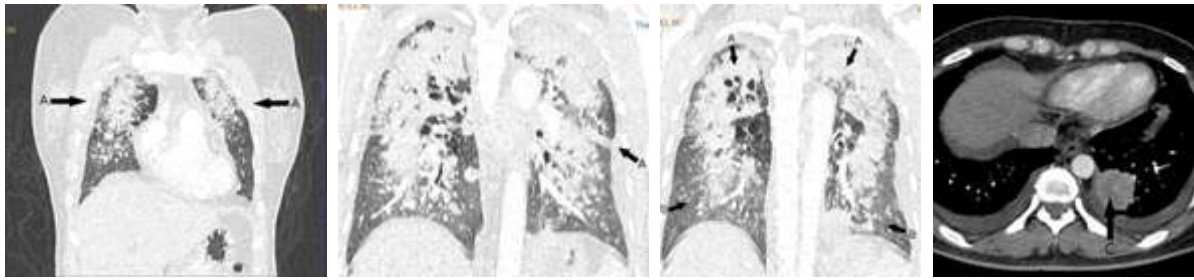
The first patient's CT scan results found tuberculosis lung (A), lung nodule in bilateral lung (B), solid mass in left lung (C).
